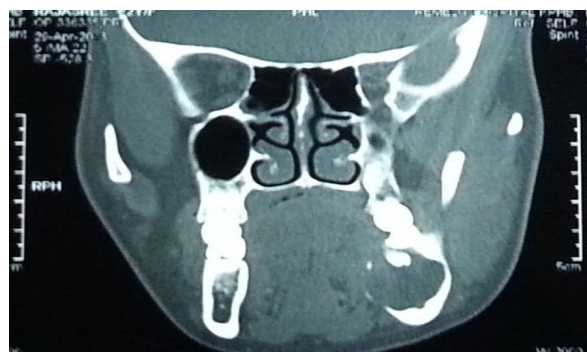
Axial view of the CT scan
